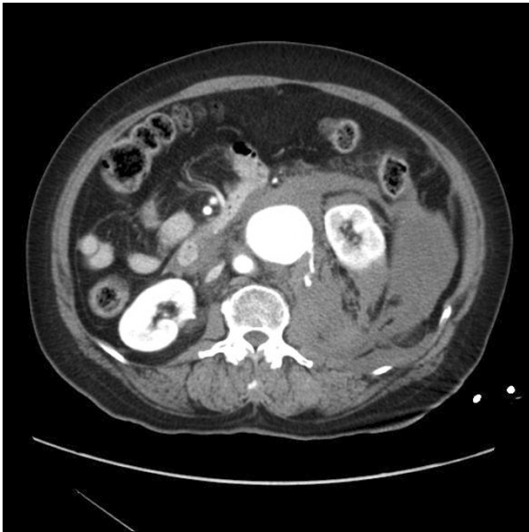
Abdominal computed tomography scan (case 1) shows left ruptured renal artery aneurysm with active bleeding. Hematoma is extended into the pelvic extraperitoneal space along the left peri- and pararenal space.
